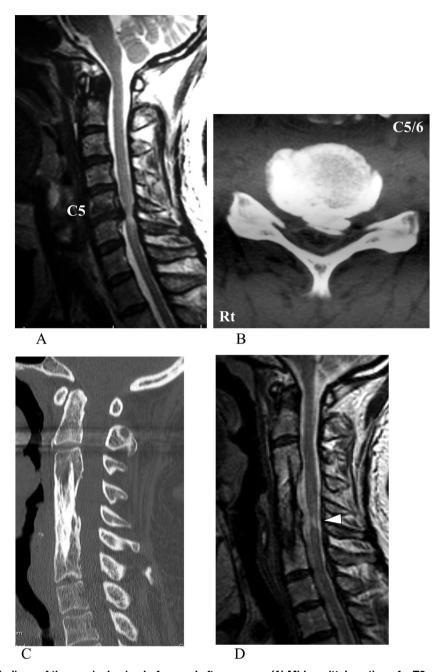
Imaging findings of the cervical spine before and after surgery. (A) Mid-sagittal section of a T2-weighted magnetic resonance image (MRI); (B) an axial section of a computed tomography (CT) myelogram at the C5/6 level before surgery, showing the OPLL that compressed the spinal cord anteriorly. (C) Mid-sagittal CT reconstruction and (D) mid-sagittal section of a T2-weighted MRI 14 years after surgery, showing that the spinal cord compression was resolved but atrophic changes of the spinal cord were present at the C5/6 level (arrowhead).
